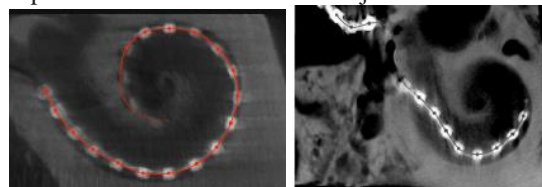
Computed tomography scan post-insertion of a cochlear implant; Left: successful insertion allowing activation of all electrodes; Right: incomplete insertion.
